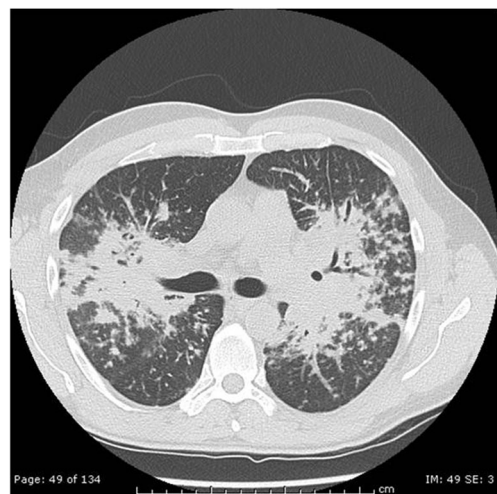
Pulmonary sarcoidosis. High-resolution computed tomography of the chest in a 52-year-old man shows a classical combination of hilar and mediastinal lymphadenopathy, perilymphatic nodules, bronchovascular and interlobular septal beading and centrilobular and subpleural nodules
